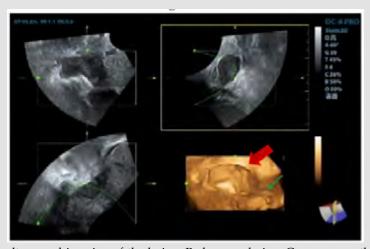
Three-dimensional ultrasound imaging of the lesion. Red arrow: lesion; Green arrow: the lesion originated from the muscularis of the cardia.
